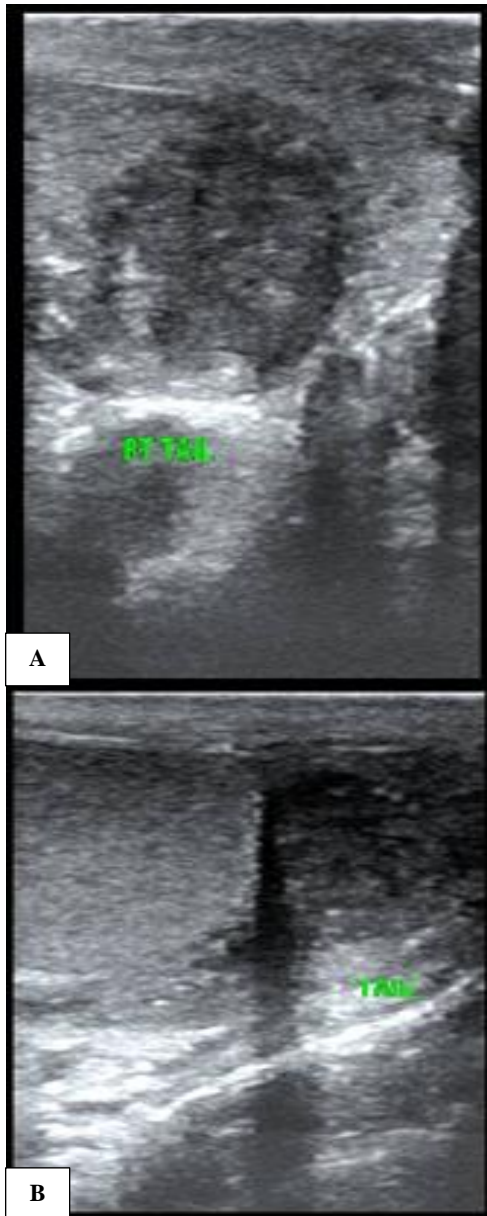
(A and B): Testicular ultrasound shows enlarged heterogeneous right epididymis.
